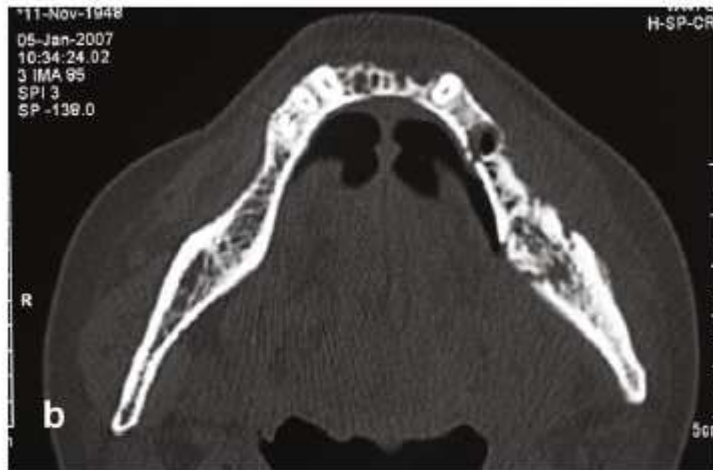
(a) Exposed necrotic bone, gingival fistulas and purulent discharge (b) Axial mandibular CT scan showing increased bone marrow density and diffuse signs of osteonecrosis/osteomyelitis.
